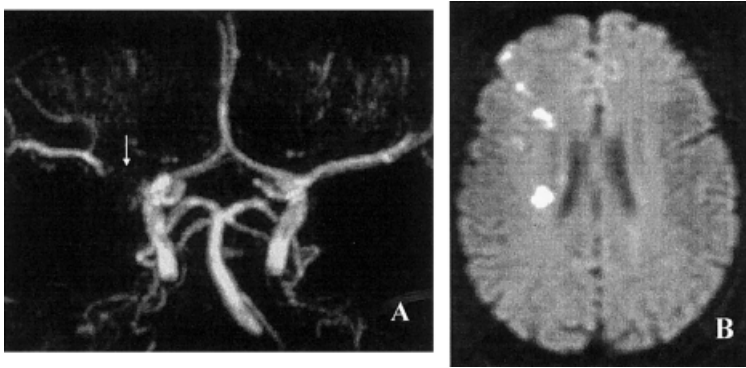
A 66-year-old woman had left-sided weakness. (A) Magnetic resonance angiography showed a severe stenosis in the right middle cerebral artery (arrow). (B) Diffusion-weighted magnetic resonance imaging demonstrated multiple chainlike small infarcts along the right anterior border zone and internal border zone regions.
